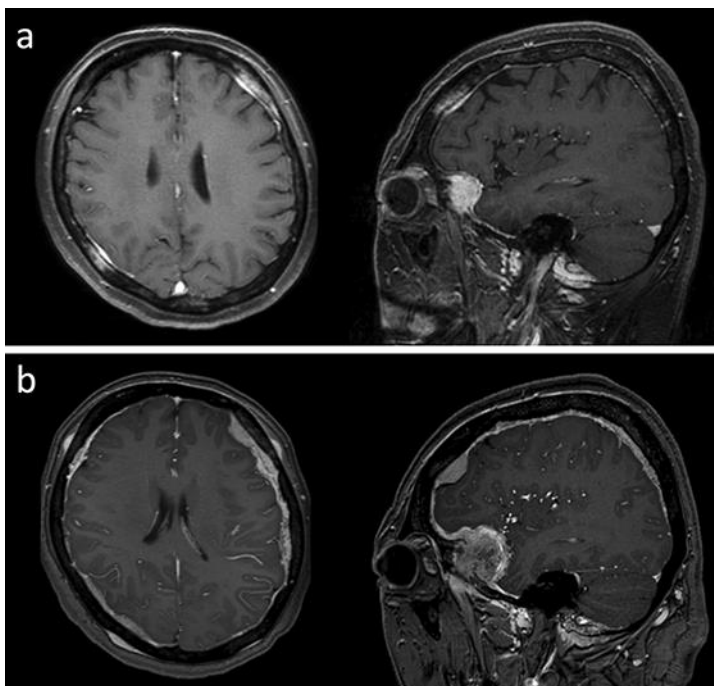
Brain MR images, (a) when the patient was diagnosed with dural metastases and (b) when the patient developed dysarthria and was hospitalized. Dural metastases indicated diffuse progression in a short period of time.
